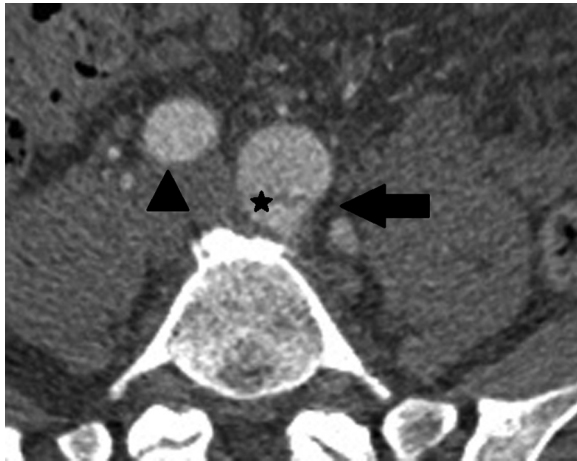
Computed tomography angiography demonstrates left common iliac artery (CIA) aneurysm (*arrow*) with dissection membrane (*asterisk*) and the right CIA (*arrowhead*).
